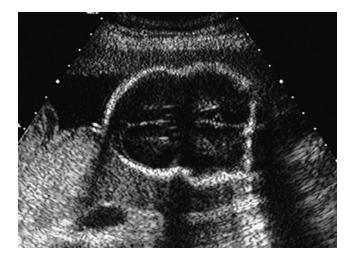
Prenatal sonographic image of a fetus at 24 weeks with bilateral coronal craniosynostosis.
